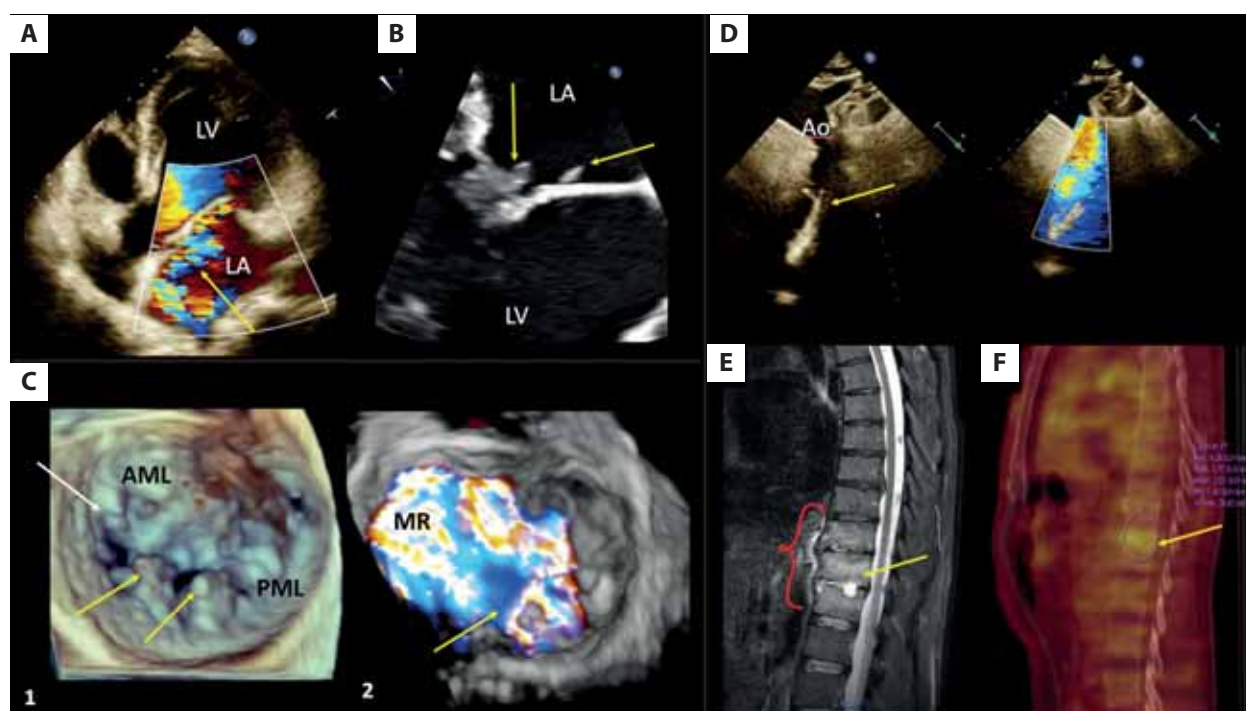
Echocardiography, magnetic resonance of the spine and PET/CT in a patient with mitral valve endocarditis. A. Eccentric jet of severe mitral regurgitation (arrow); two-dimensional transthoracic echocardiography, color Doppler (Supplementary material, *Video S 1*). B. Mitral valve infective endocarditis; bacterial vegetations attached to the mitral leaflets (arrows); 2-dimensional transoesophageal echocardiography; C. Bacterial vegetations attached to the posterior mitral leaflet (yellow arrows) and the anterior leaflet (white arrow) (1) and a wide jet of mitral regurgitation on color Doppler (arrow) (2); 3-dimensional transoesophageal echocardiography (Supplementary material, *Video S2*); D. Descending aorta at the level of the previous coarctation surgery (arrow); 2-dimensional transthoracic echocardiography (left panel), color Doppler (right panel). E. Spondylodiscitis: infectious lesions at the levels of Th10/Th11 and Th11/Th12 (arrow) and an inflammatory infiltrate in the paravertebral soft tissues (red brace); contrast-enhanced magnetic resonance. F. Post-inflammatory lesions in the spine (arrow); positron emission tomography/computed tomography
